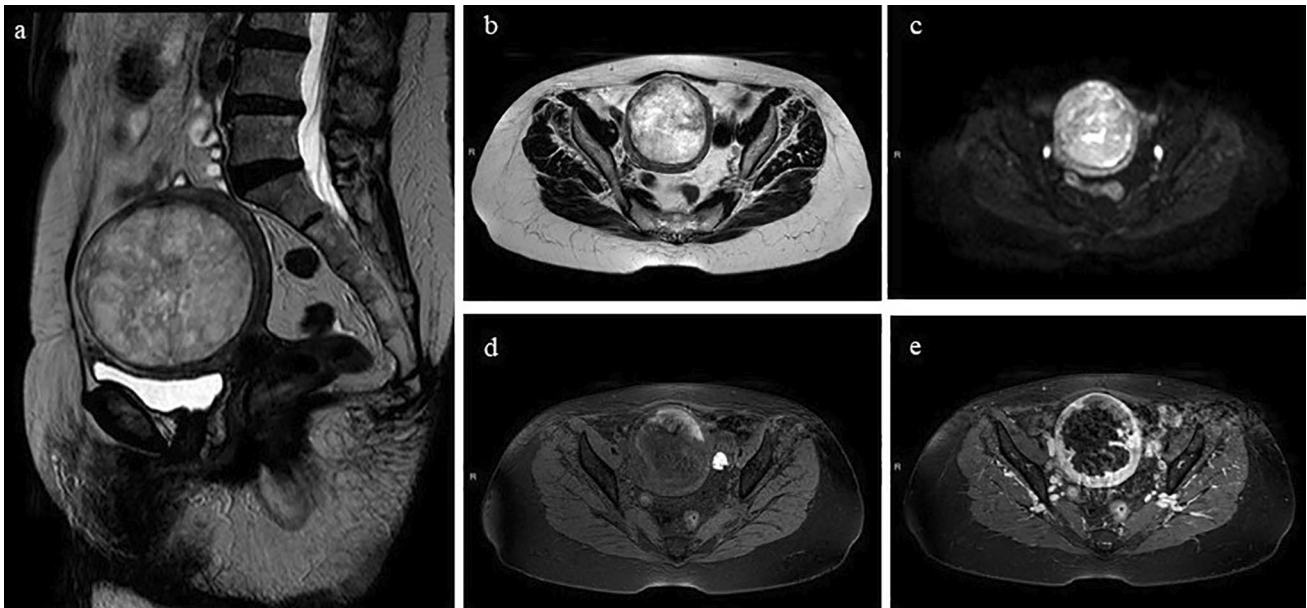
Uterine adenocarcinoma: sagittal a and axial b T2WI showed a heterogeneous hyperintense uterine lesion with smooth margins; the lesion was characterized by restricted diffusion on DWI c. T1FS WI
